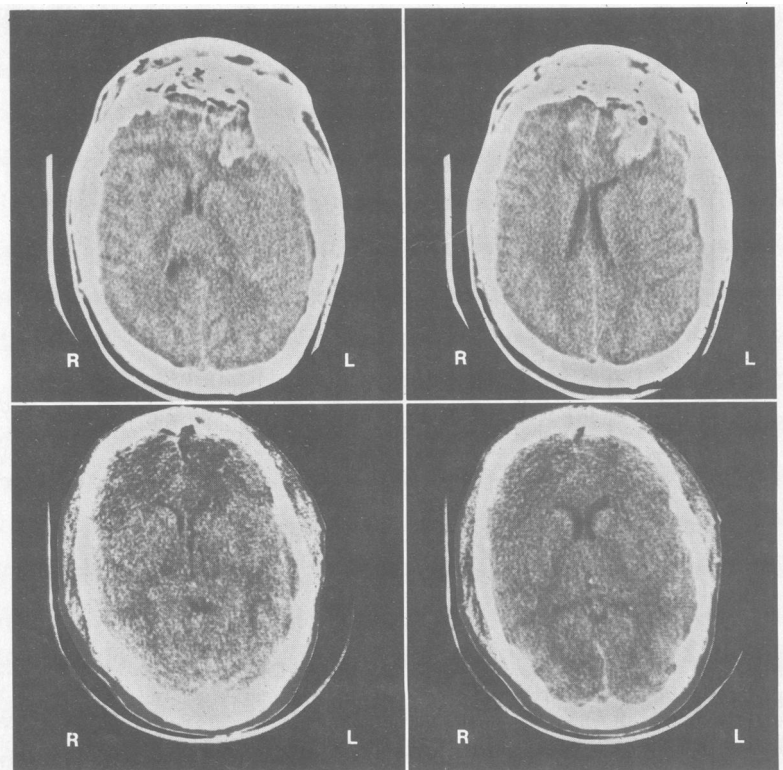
Top, Computed tomographic scans were taken of a 19-year-old UCLA football player who sustained a bi-frontal skull fracture and hemorrhagic contusion after a fall. The patient was confused with intermittent lethargy but without focal deficit. He underwent craniotomy with complete resection of hematoma and contused tissue. Bottom, Scans taken 5 days postoperatively show mild edema but no evidence of hematoma or hemorrhagic tissue. Clinically the patient did well, returning to school 6 weeks after the operation. The only deficit was anosmia.
